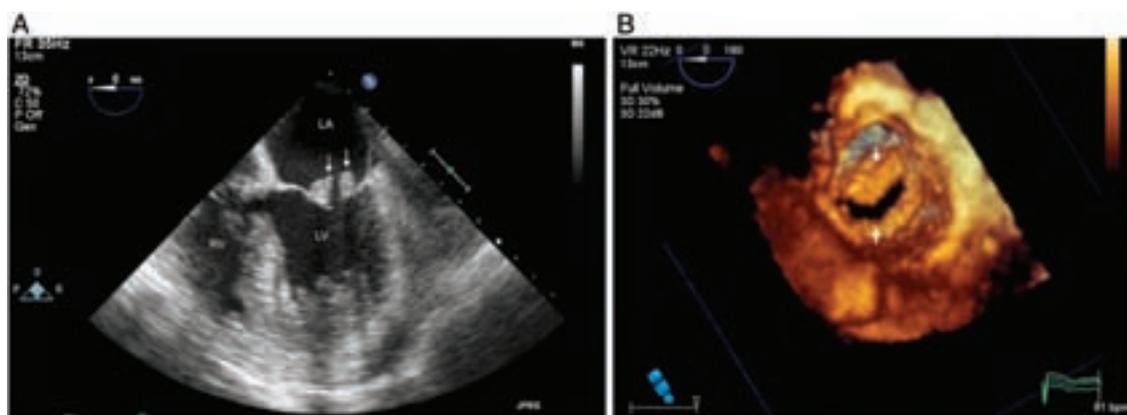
Transoesophageal apical four-chamber and 3D reconstruction in an 86-year-old woman with marantic endocarditis, in the setting of metastatic pancreatic cancer. Please note the diffuse involvement of the edge of the anterior and posterior leaflets.
